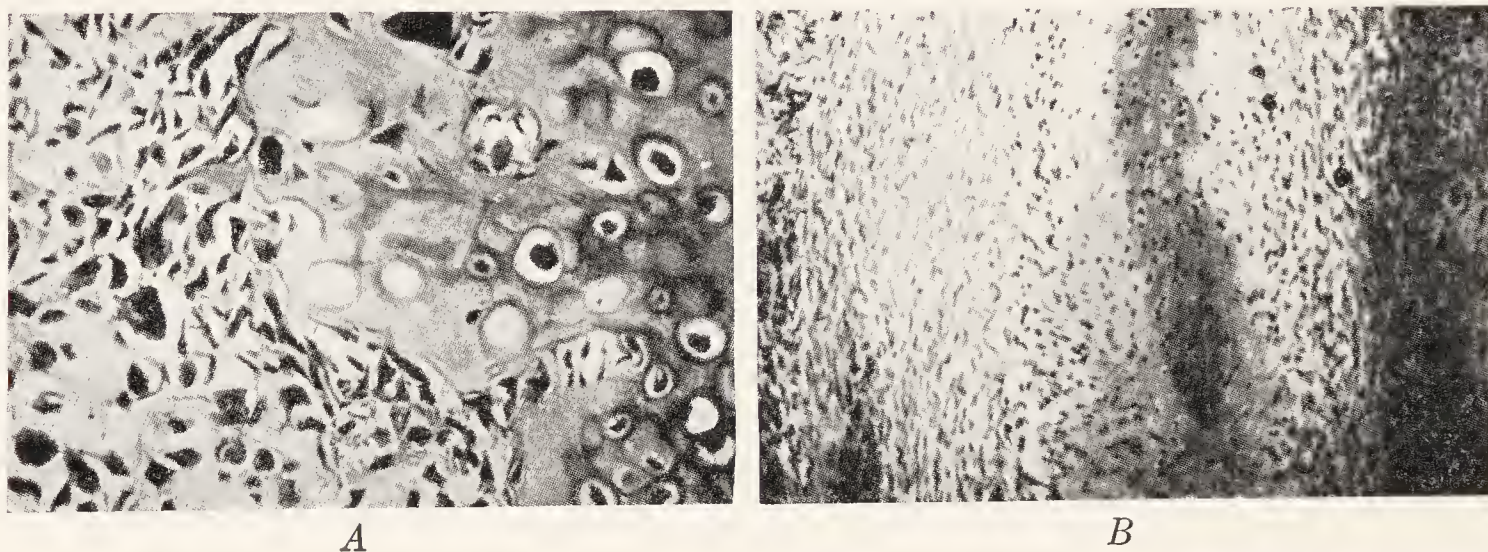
A, Primary osteogenic sarcoma. One month after operation it recurred. Recurrent tumor more rapidly growing than primary tumor. (After Thoma.) B, Rapidly growing embryonic type of tumor, with cartilage and adjacent osteoid tissue. The cellular elevation shows low-grade differentiation. Osteogenic sarcoma. Age, twenty-five. Registry of bone sarcoma, Case No. 404. Left lower jaw is occupied by a hard mass. Roentgenogram of mandible shows some new bone formation along with bone destruction. See roentgenogram in Fig. 290, A.
